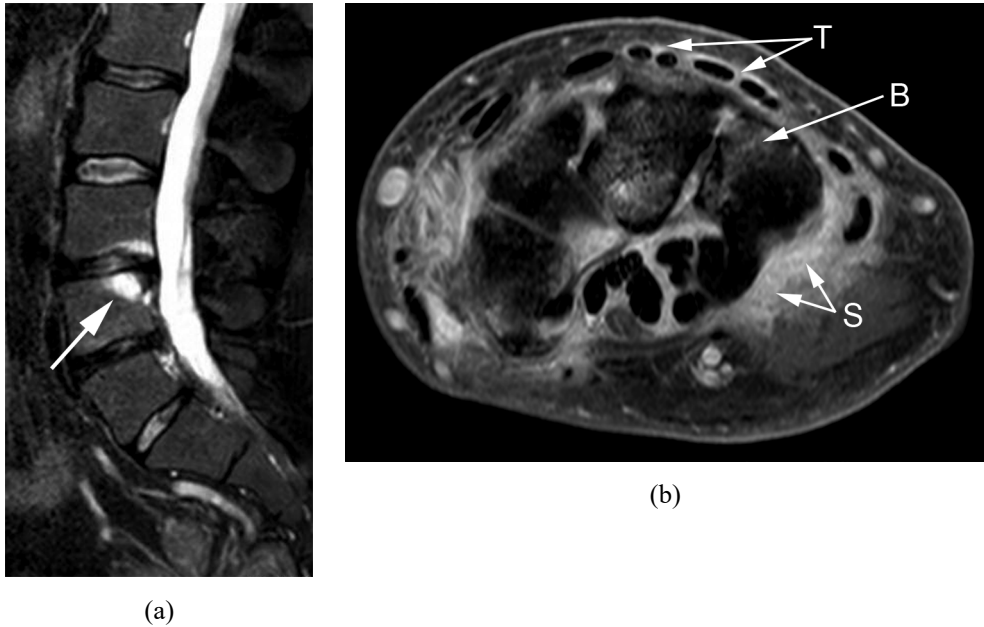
MRI-detected inflammatory features seen in axial SpA and RA. Axial SpA (a): STIR sagittal MRI of the lower spine, fat suppression forces healthy bone marrow to appear dark, while bone marrow edema in the vertebra appears as a region of high intensity (arrow). RA (b): T1-Gd axial MRI of the wrist, combination of fat suppression and post-contrast enhancement reveals bone marrow edema (B arrow), synovitis (S arrows), and tenosynovitis (T arrows) as regions of high intensity.
